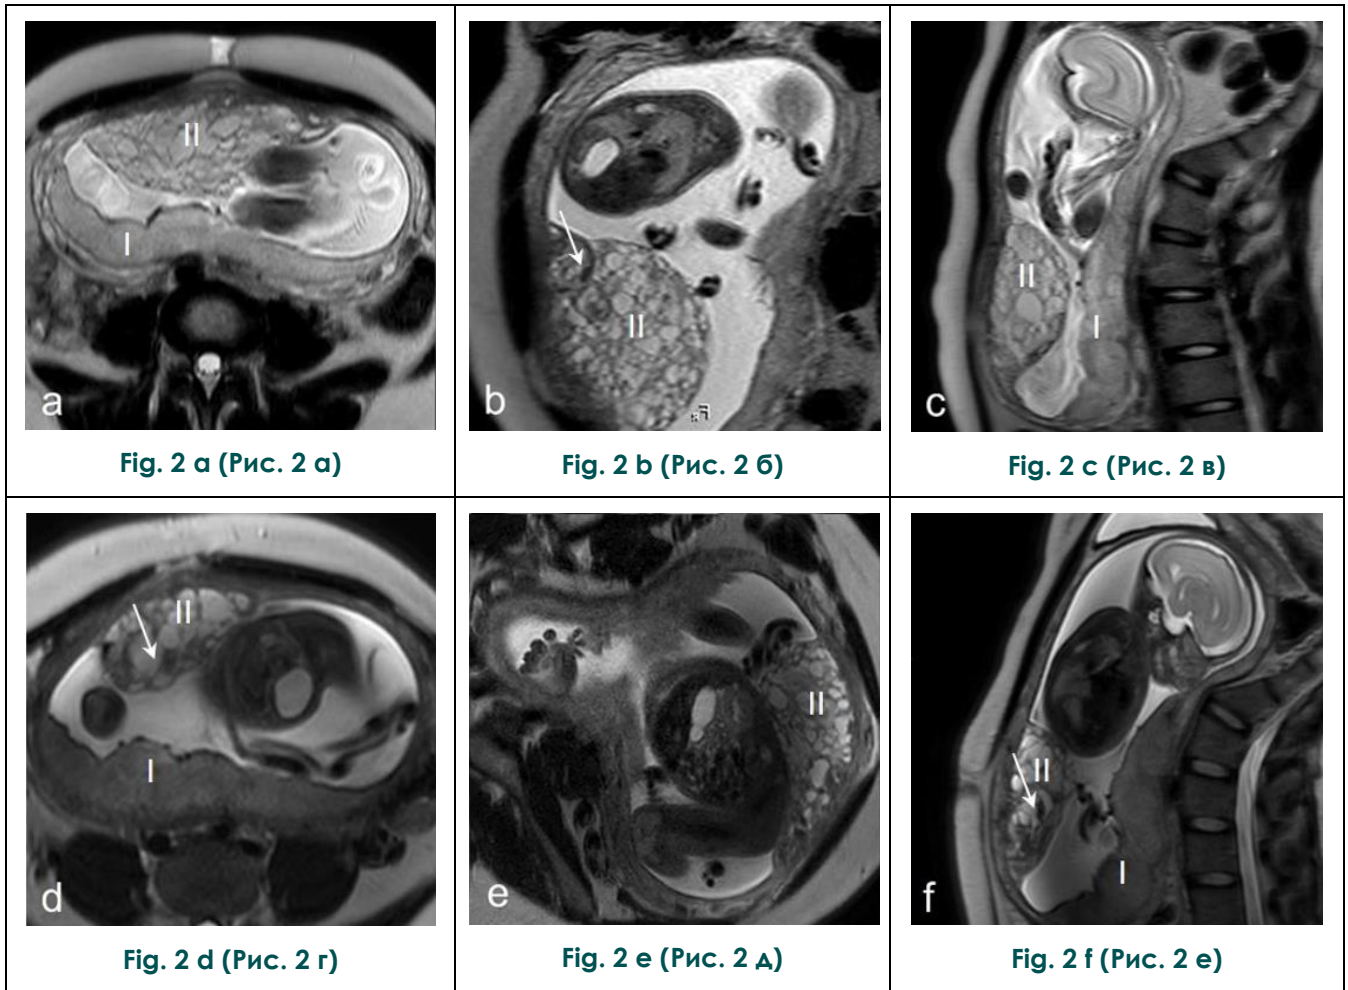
MRI at 23 weeks (top row) and 26 weeks (bottom row), a,d – axial, b,e – frontal, c,f – sagittal section (relative to the pregnant woman).
